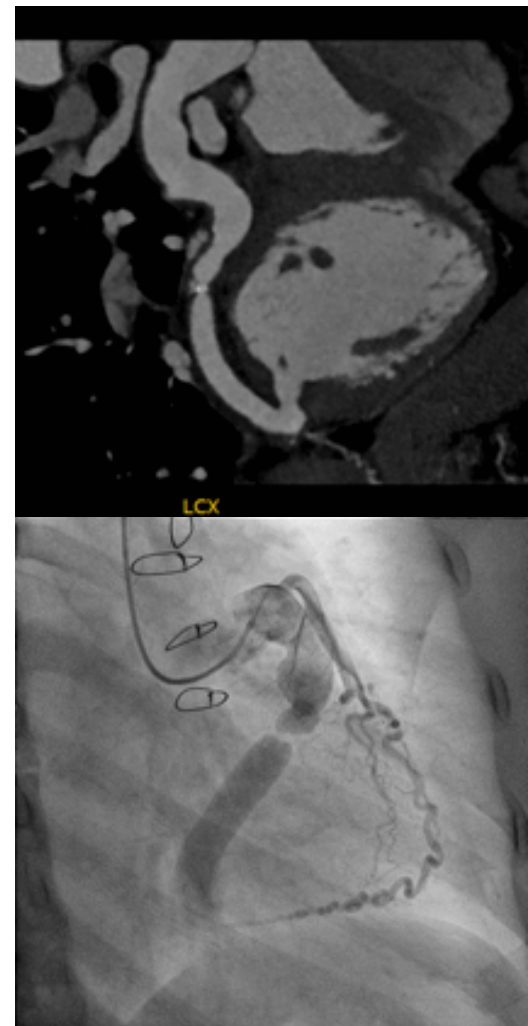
Pre-procedural CT and coronary angiogram
